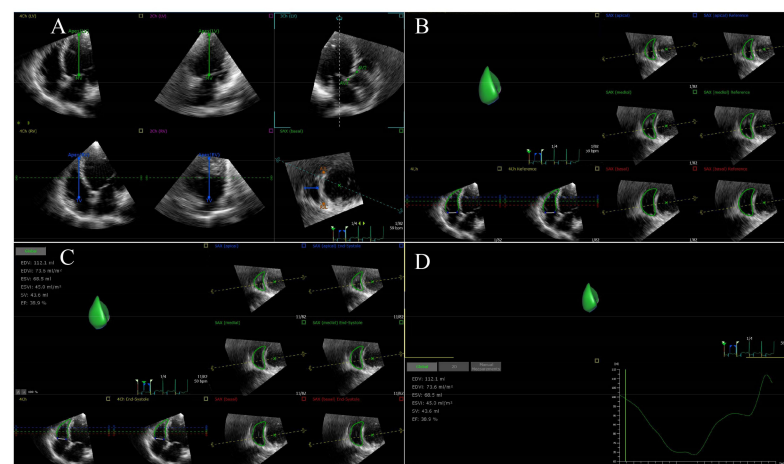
RVEF using 3 DE in a patient with HF rEF. (A) Setting reference points; (B) RV endocardial border identification and tracking at end-diastole; (C) RV endocardial border identification and tracking at end-systole; (D) RVEF is automatically generated. RVEF, right ventricular ejection fraction; 3 DE, three-dimensional echocardiography.
